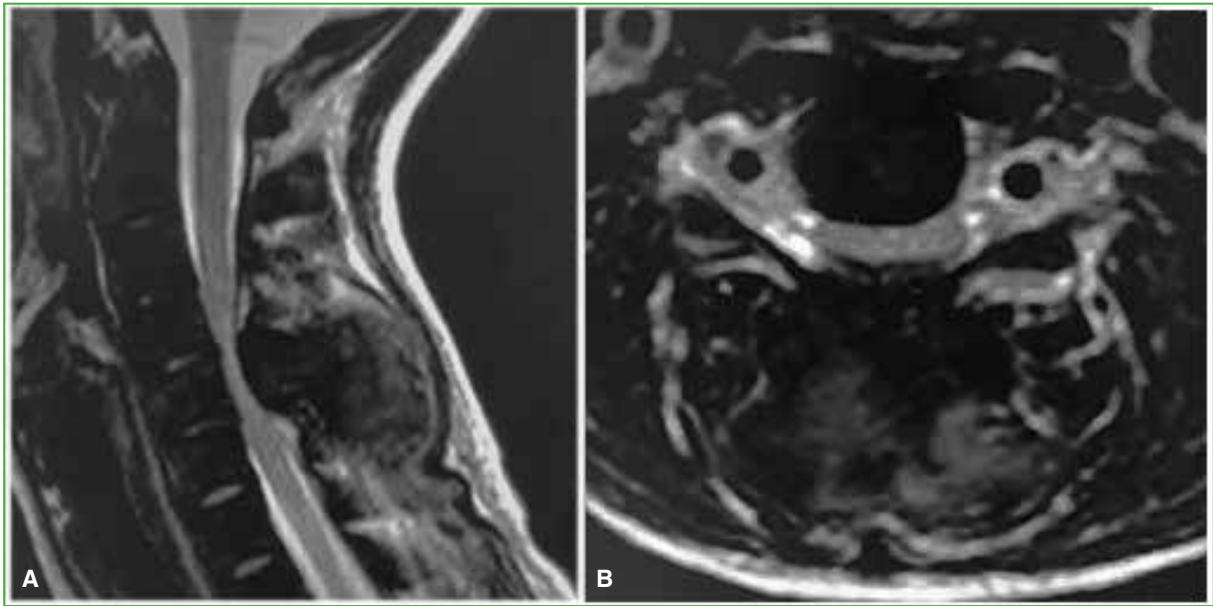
Magnetic resonance imaging of the cervical spine. A. Sagittal section. B. Axial section. The tumor involves the posterior arch of C5 and the adjacent soft tissues, resulting in spinal cord compression at this level.
